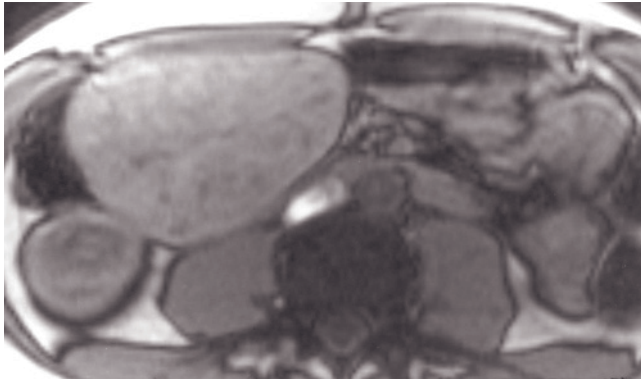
Adenomatosis. Coronal (a, b) and transverse (c, d) T2-weighted SS-ETSE, coronal (e) and transverse (f, g) SGE, out-of-phase SGE (b, i), and immediate (j, k) and 90-s fat-suppressed (l, m) postgadolinium SGE images. Multiple small lesions are
